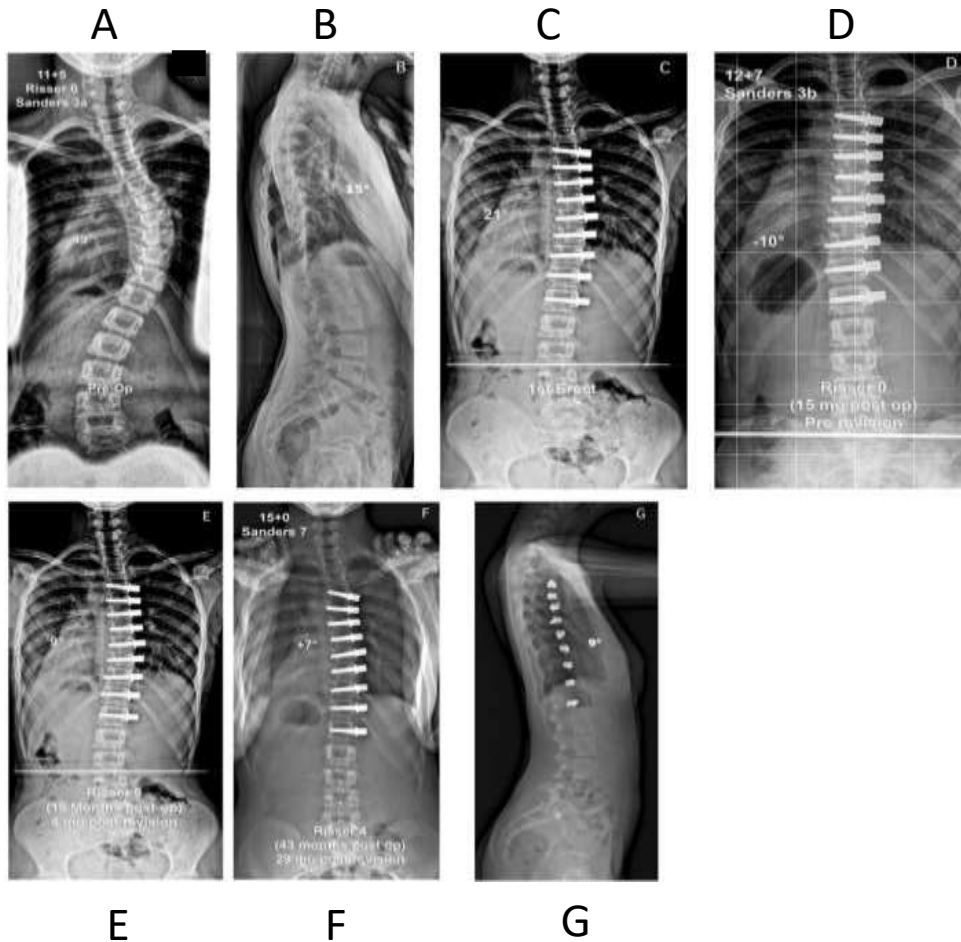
Example of anticipated revision for overcorrection in 11.5-year-old girl (Risser 0, Sanders 3A). (A) Presenting coronal x-ray with worsening trunk shift. (B) Pre-op lateral x-ray. (C) First erect x-ray following T5-L1 ASC. (D) Follow-up PA radiographs at 15 months postoperatively show overcorrection of 10°. (E) 4-month post-revision. A longer cord was used to address overcorrection. (F) 29 months post revision surgery (43 months post index procedure). The patient is now Risser 4, Sanders 7. Correction is maintained. (G) Post-op lateral x-ray at 43 months post index procedure. We did not do disc releases on this patient, and therefore there was no correction of the hypokyphosis. This case and others have led to us doing routine disc releases on these immature patients to help obtain normal kyphosis.
